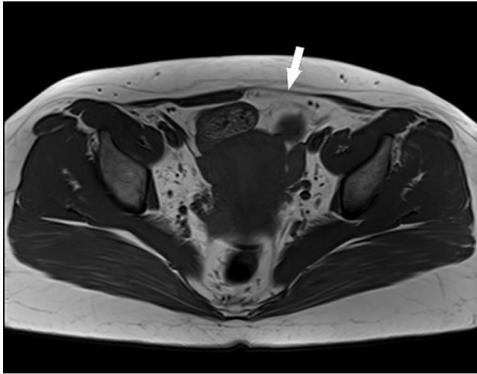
MRI ("Pelvic MRI from 2017 with no identifiable left rectus abdominis muscle.").
